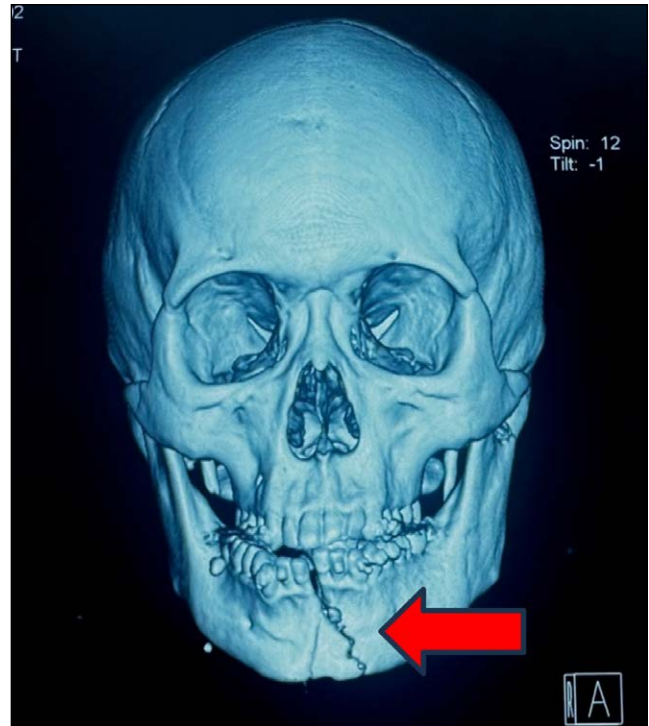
Computed tomography (CT) scan showing mandibular symphysis fracture
